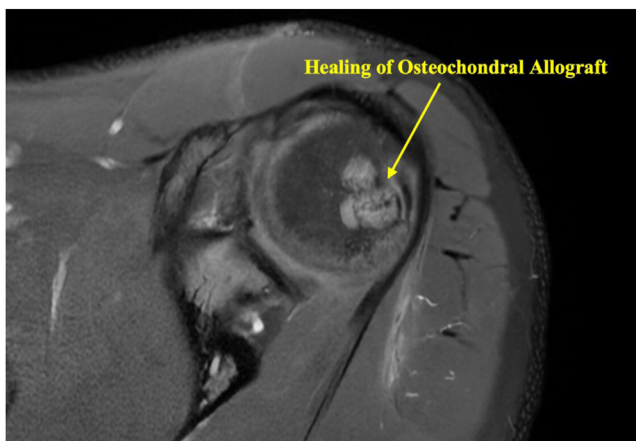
Axial magnetic resonance imaging of the left shoulder 2 months postoperatively demonstrates healing of osteochondral allografts in the humeral head.
